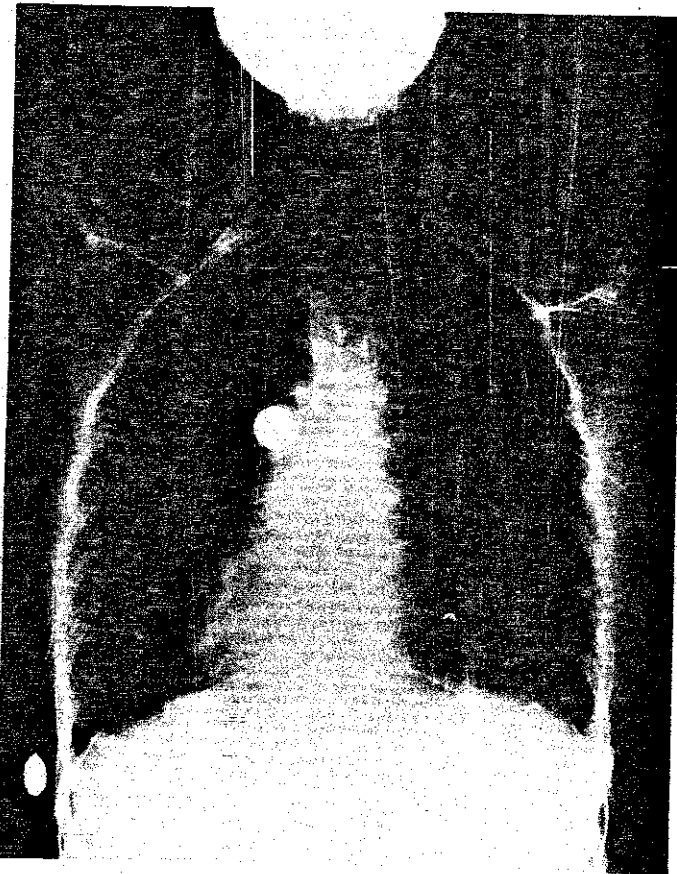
Chest X-ray showing true dextrocardia.
